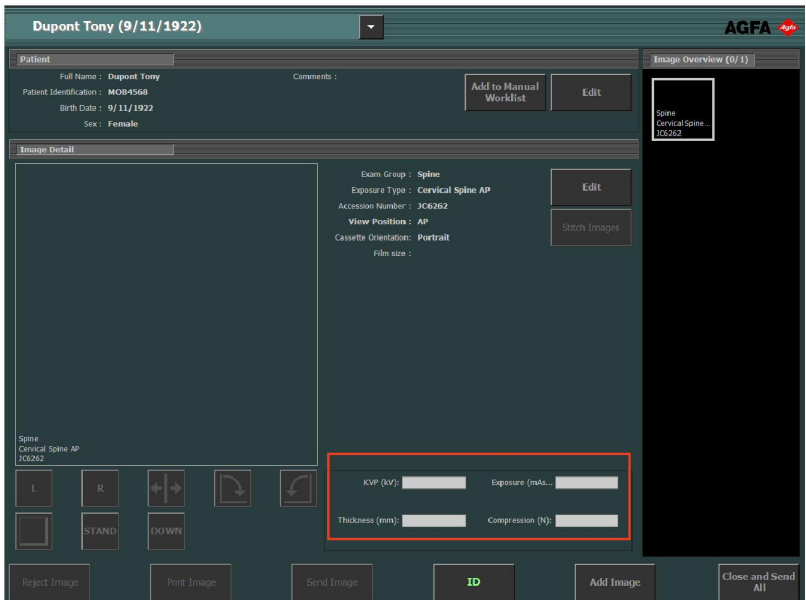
X-Ray parameters in Examination window
